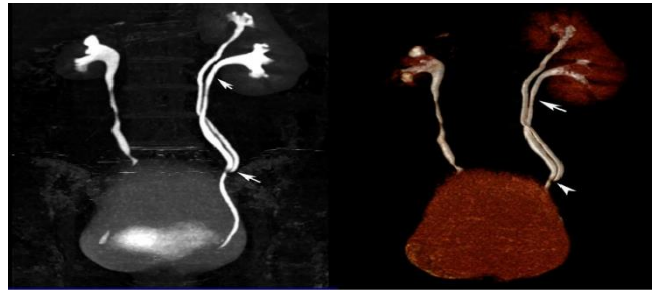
3D volume rendering maximum intensity projection image of CT Urography in a study patient showing duplication of collecting system, upper and mid ureter (arrow). Both the ureters are joining in their lower thirds (arrow head).
